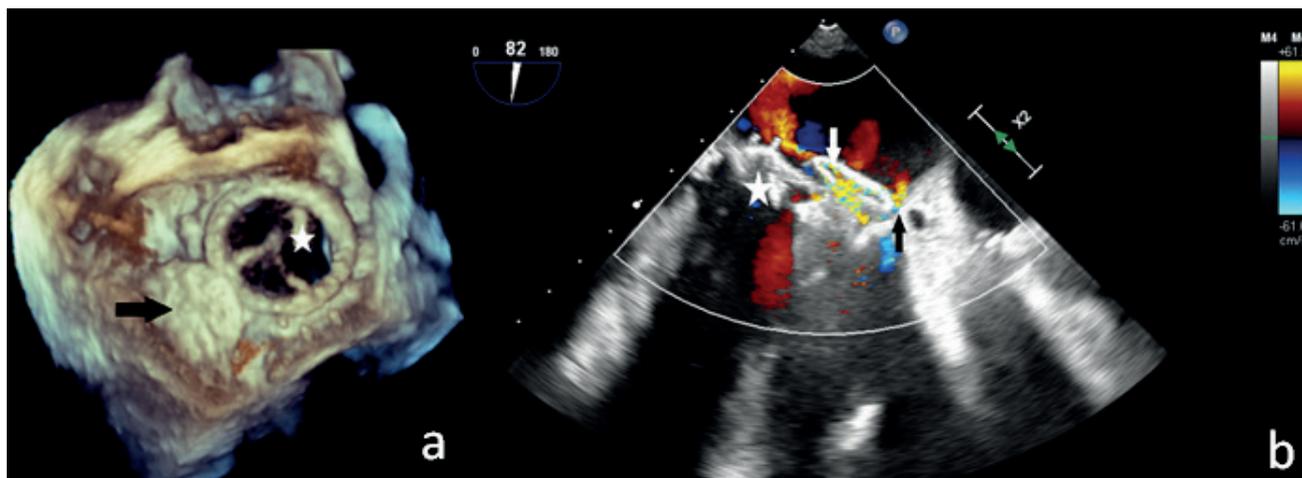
A) 3D transoesophageal echocardiography image of the closure device in situ (black arrow) next to the mitral bioprosthesis (asterisk). B) Residual regurgitation between the mitral bioprosthesis (asterisk) and the closure device, with one large jet (white arrow) through the device and one small jet (black arrow) to the lateral side of the device
